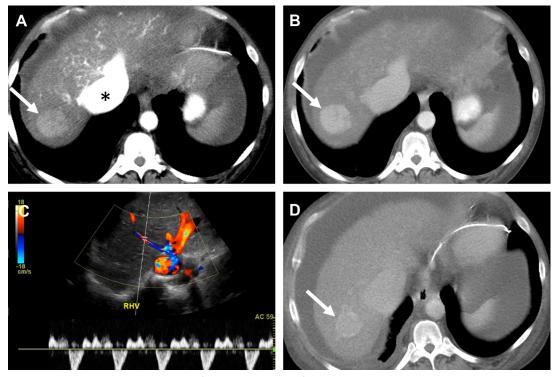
A 45-year-old man with history of severe diastolic dysfunction and tricuspid regurgitation. Axial contrastenhanced CT (*A*) shows an avidly arterially enhancing lesion in segment 7 (*arrow*) which remained hyperdense during the venous phase (*B*). Note the reflux of contrast into IVC (*asterisk*) during the arterial phase. Doppler US (*C*) shows abnormal hepatic venous waveform classic for severe tricuspid regurgitation. Contrast-enhanced CT obtained 3 years later (*D*) shows mild decrease in size of the lesion over time.
